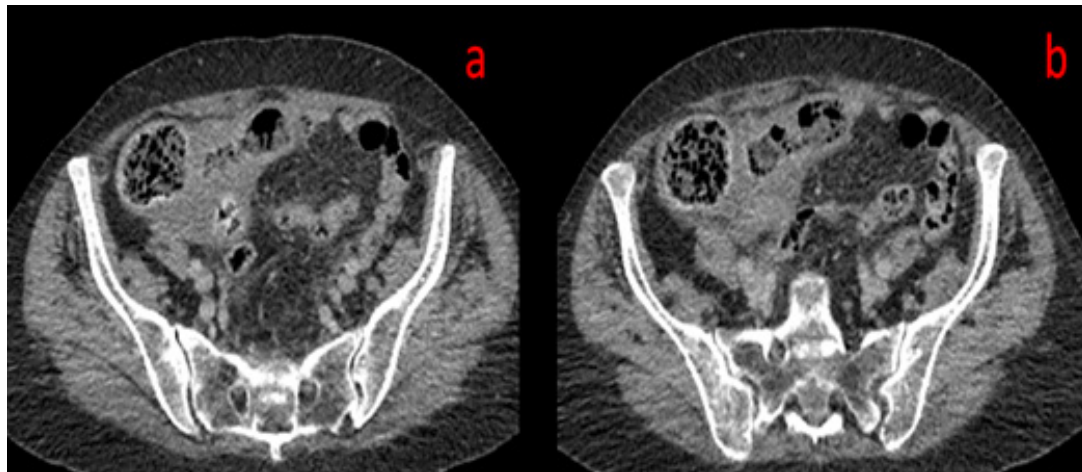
Tissue edema and tumoral formations at the level of ileocecal valve on axial abdominal CT images.
